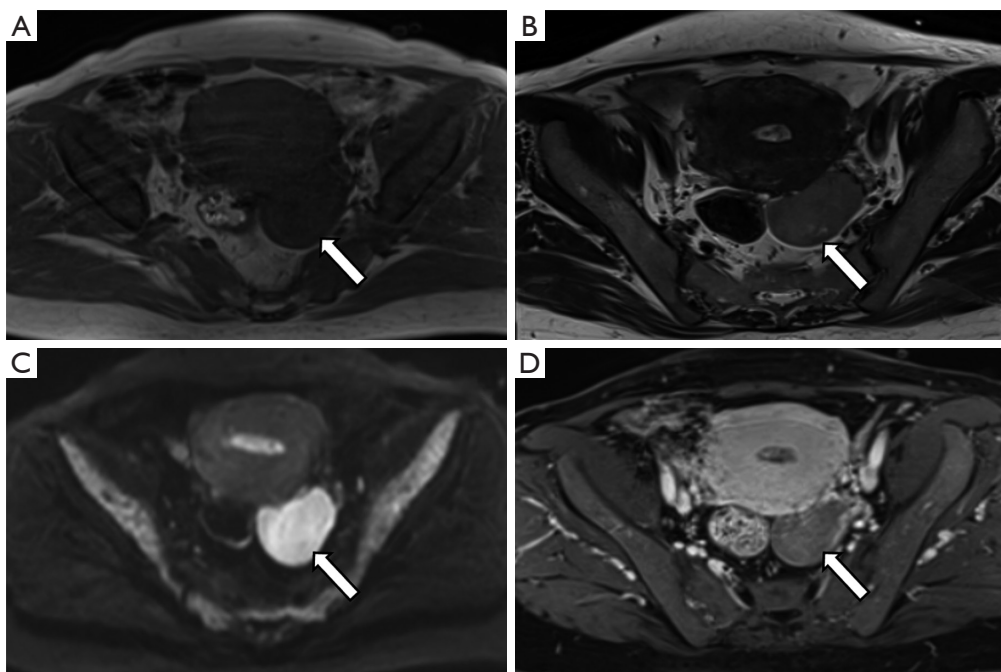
MRI scans showed a mass in the left adnexal area (white arrow). (A) The mass was isointense on T1WI as compared to the myometrium, containing slightly lower SI area and (B) slight hyperintensity in T2WI with higher SI areas in it. (C) DWI showed diffusion restriction. (D) The tumor was progressively and inhomogeneously enhanced, and the enhancement degree in the delayed phase was lower than that for the myometrium. MRI, magnetic resonance imaging; T1WI, T1-weighted imaging; SI, signal intensity; T2WI, T2-weighted imaging; DWI, diffusion-weighted imaging.
